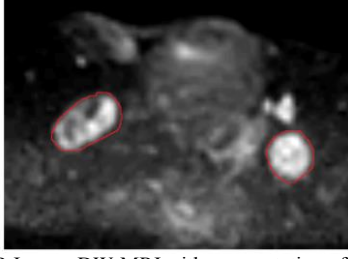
DW-MR Image: DW-MRI with segmentation of malignant LNs (outlined in red). In a DW image, malign LNs appear with a high intensity compared to benign LNs, hence the advantage of using this sequence in LN segmentation.
